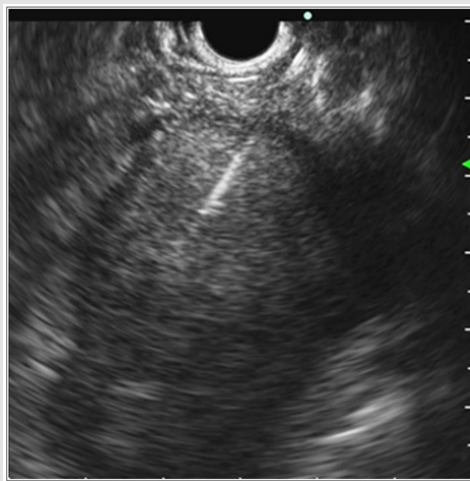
Endoscopic ultrasound (EUS) image showing a small neuroendocrine tumor (NET) of the pancreatic head, consistent with a gastrinoma (arrow).
